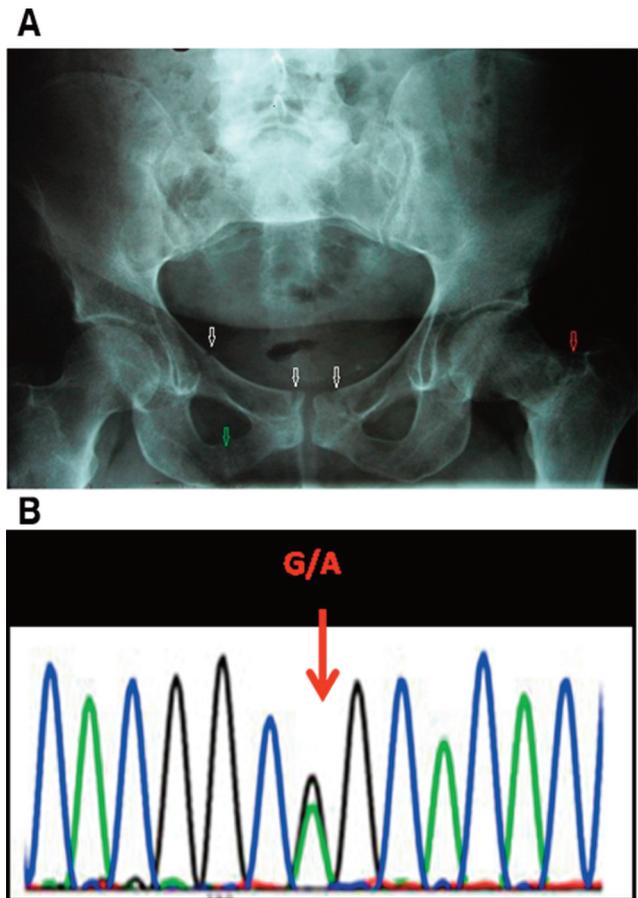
(A) Hip and pelvis radiograph: Transcervical fracture of the left femur with delayed union (red arrow) and varus deformity. Looser's zones on pubic rami (white arrows) and on the right ischial ramus (green arrow). (B) Sequence chromatogram covering the detected p.R176Q mutation identified in ADHR patient amplified from genomic DNA (QIAamp DNA Blood Mini Kit (QIAGEN)). Genomic DNA wild-type sequences were obtained from GenBank. The red arrow indicates the 527G>A (arginine to glutamine) mutation's site detected.
